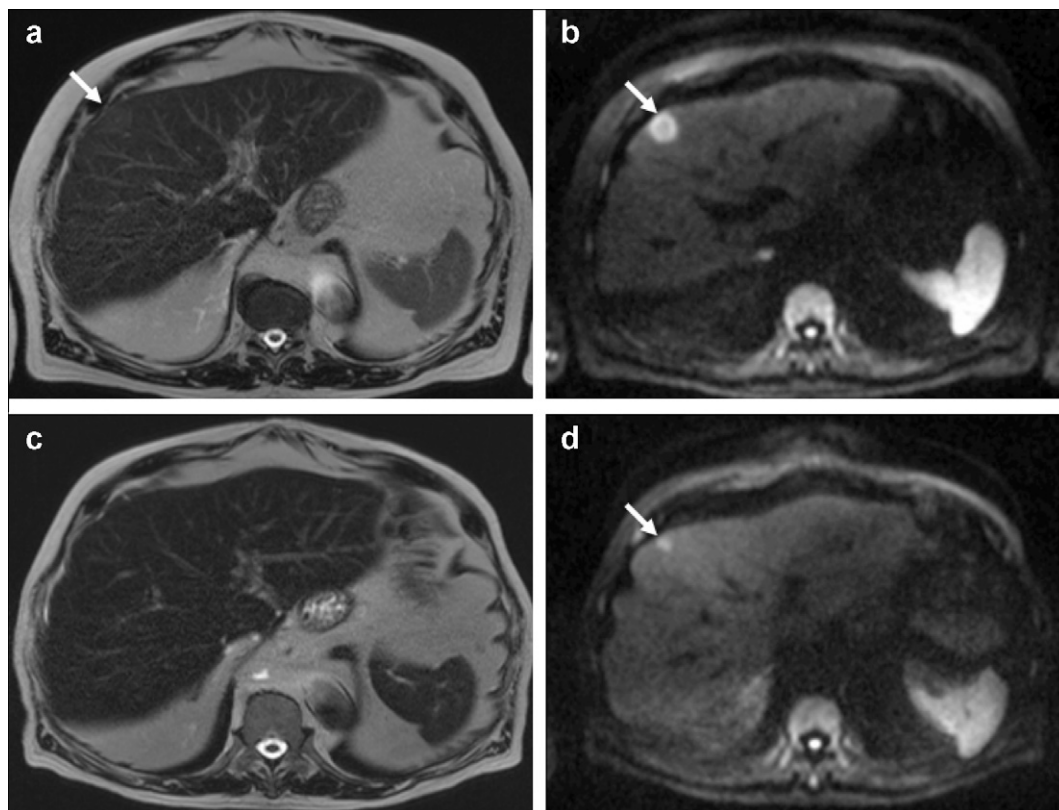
T2W HASTE (TE 241ms) images with corresponding $b = 750$ images through the liver pre (a) and post (b) chemotherapy in a patient with a metastasis from colon cancer. The metastasis is barely visible on the pre-treatment T2-w images but easily seen on DWI (c). After treatment residual.
